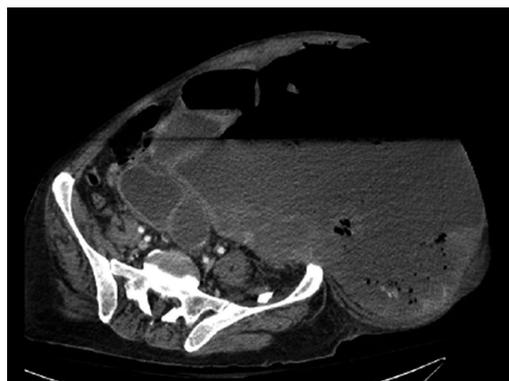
Abdominal computed tomography on admission.
